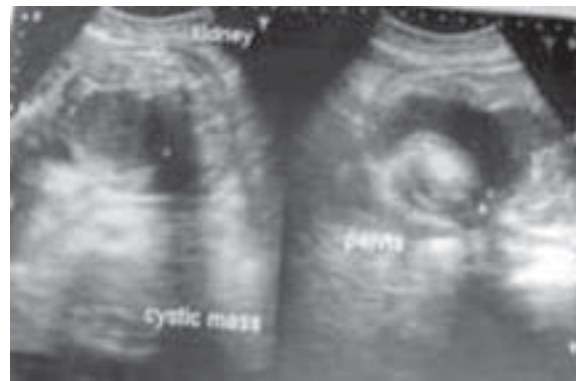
Transverse and sagittal antenatal ultrasound scans at 34 weeks of gestation showing a complex cystic mass in fetal pelvis. A diagnosis of dermoid cyst was given.
